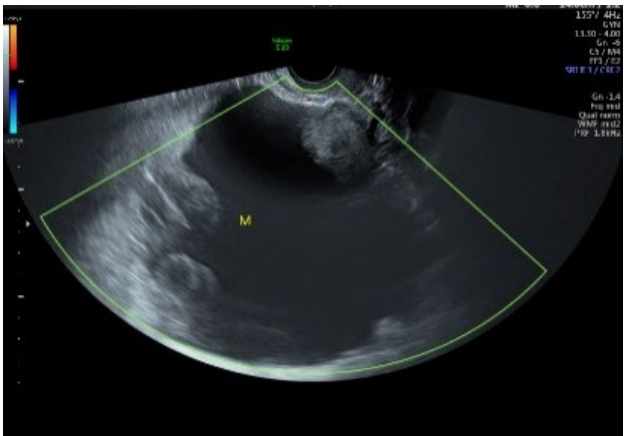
Transvaginal ultrasound
